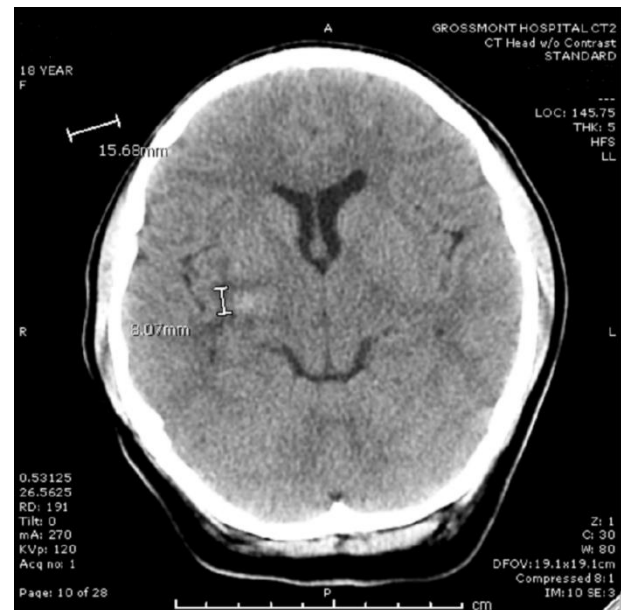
Computed Tomography (CT) of the brain without contrast showing amorphous focus of hyper-density measuring approximately 1.5 x 0.8 x 1 cm consistent with acute hemorrhage centered in the posterior right putamen/posterior limb of the right internal capsule with a rim of hypodensity consistent with vasogenic edema.
